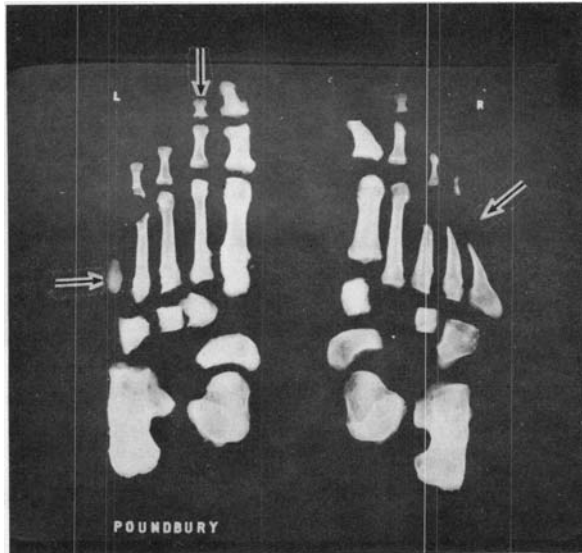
Radiograph of the feet of the Poundbury Roman leprosy skeleton.
